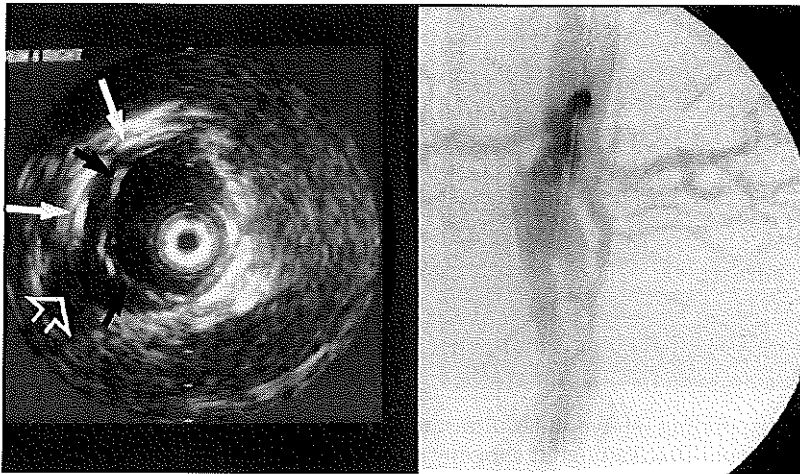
Intravascular ultrasound cross-section obtained after intervention showing a small gap between the aortic wall (white arrows) and the proximal border of the Excluder stent-graft (black arrows). The right renal artery is seen at 8 'o clock (open arrow). The angiogram revealed no endoleaks. Calibration = 5 mm.
